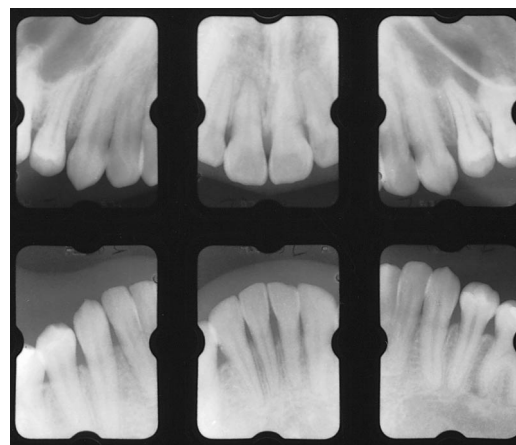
Periapical radiographs (retention).
